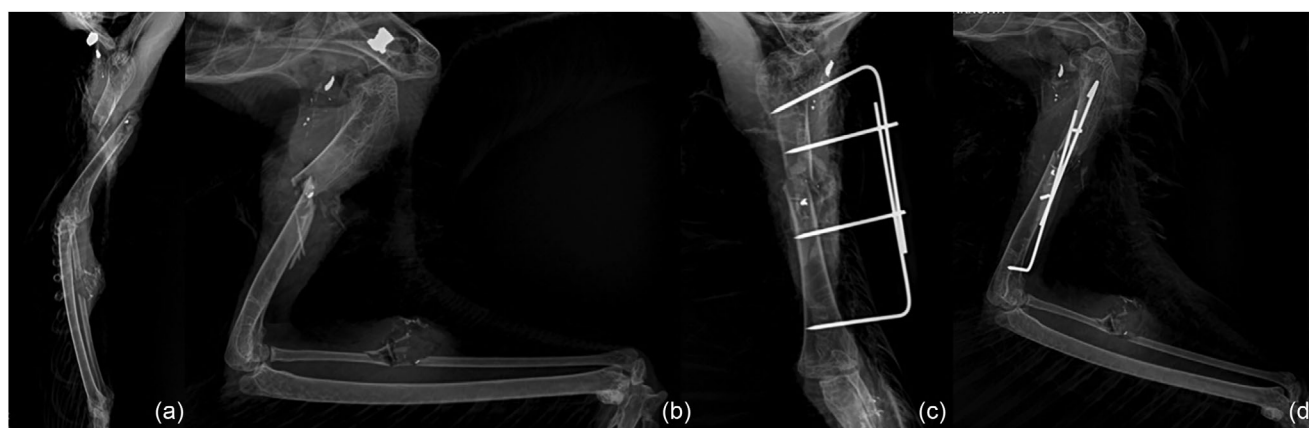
Radiographs of the left thoracic limb in caudocranial (a and c) and mediolateral (b and d) views. Preoperative images (a and b): comminuted fracture in the mid-diaphysis of the humerus with displaced fragments, and comminuted fracture of the proximal third of the radial shaft. Postoperative images (c and d): humeral fracture stabilised with a unilateral Type Ia external skeletal fixator.
